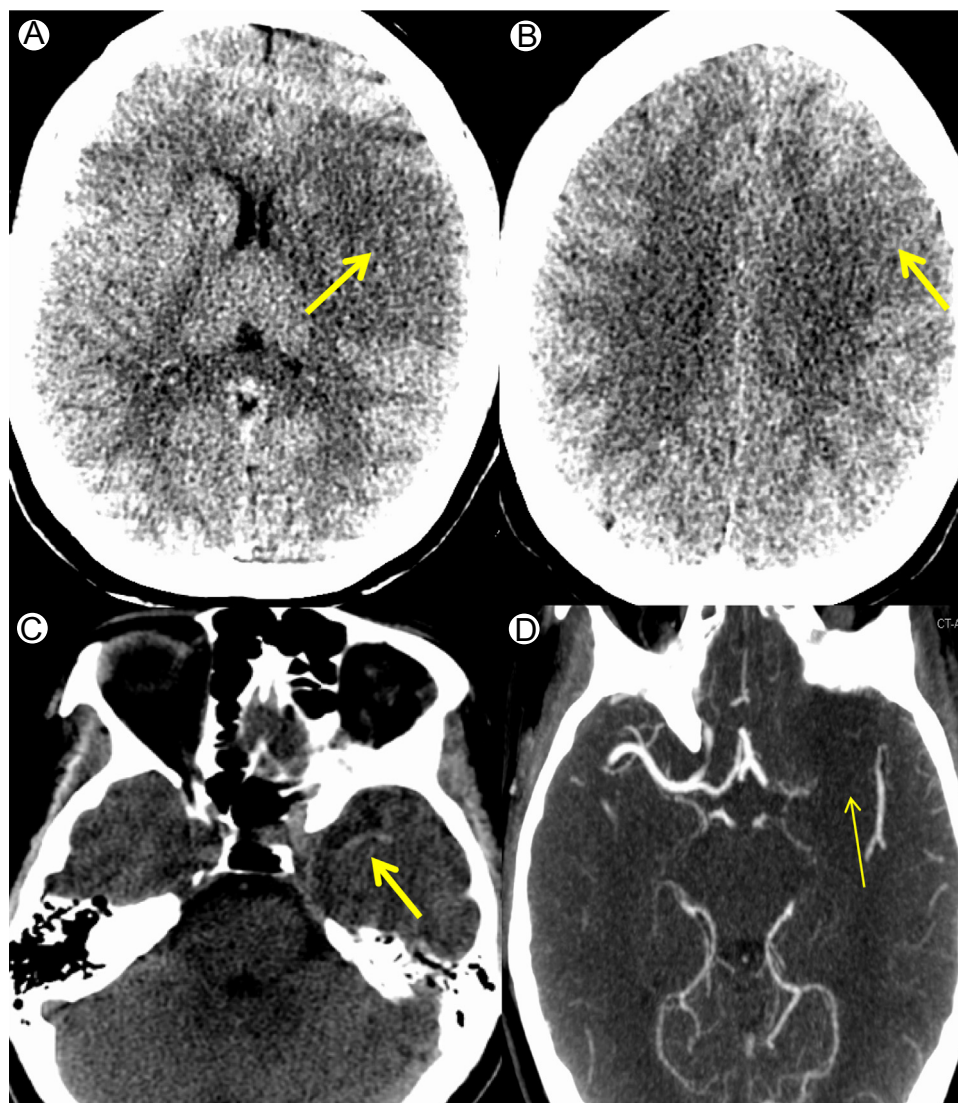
CT parenchymal and vascular findings in acute stroke. A 45-year-old male with right-sided weakness, 5 hours since last known prior. Axial noncontrast CT images (A-C) demonstrate hypoattenuation and loss of gray-white differentiation in the left MCA distribution with involvement of the internal capsule, lentiform nuclei, and insular cortex (arrows on A and B). There is a left “hyperdense vessel” sign (bold arrow on C) indicative of left M1 thrombus. Axial CT angiography image (D) confirmed the occlusive thrombus (arrow). (Color version of figure is available online.)
